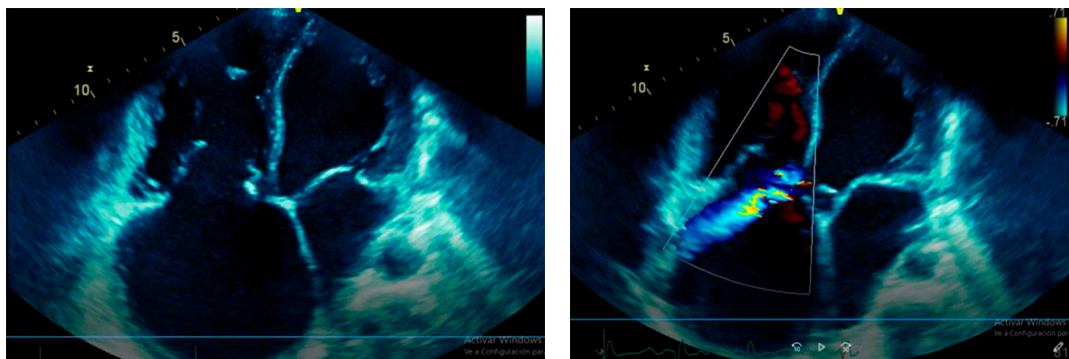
Color Doppler echocardiogram: Apical 4 chambers: Dilatation of right cavities. With color Doppler, a communication is observed between the ruptured right Valsalva sinus aneurysm and the right atrium.
